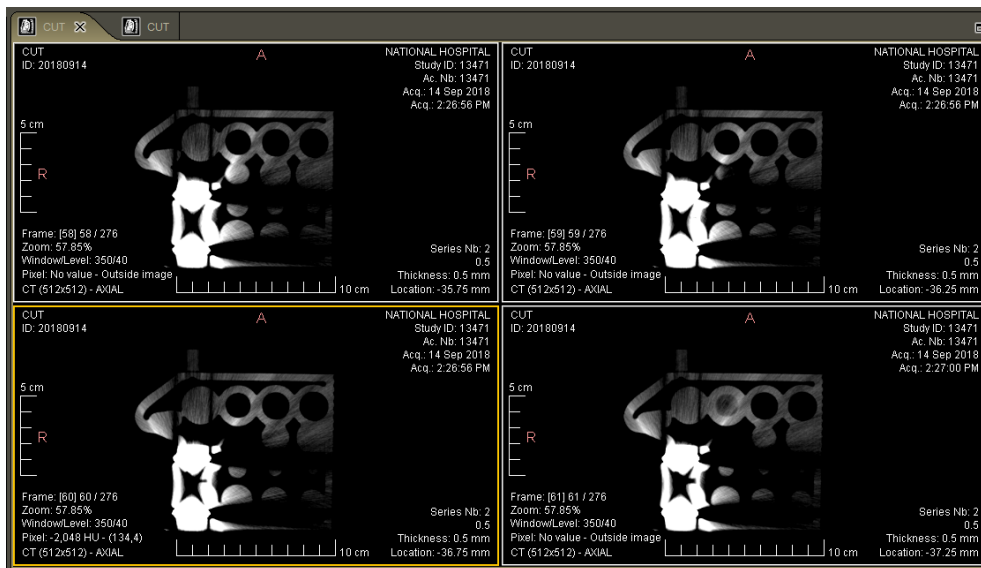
Sample of the DICOM images produced through CT scanning.
